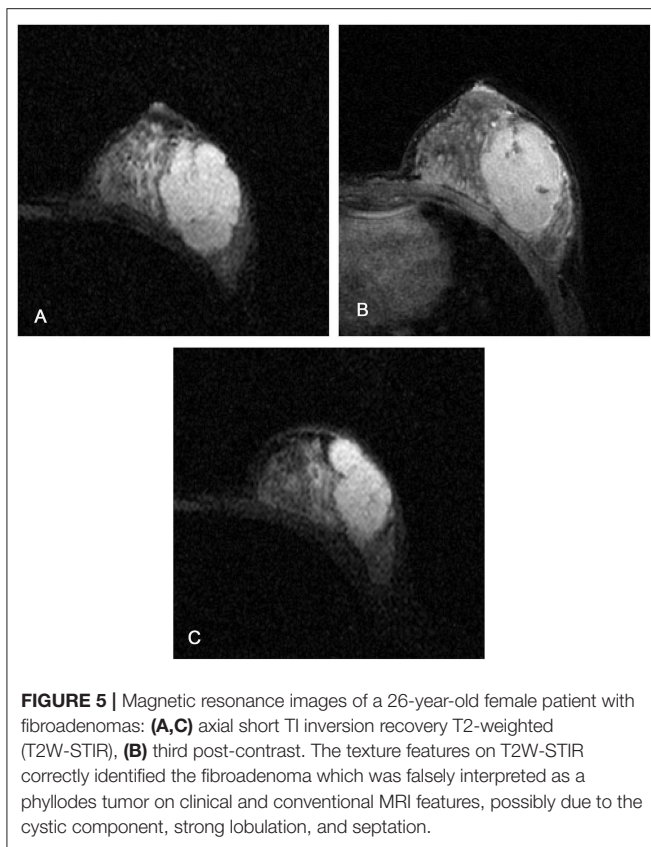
Magnetic resonance images of a 26-year-old female patient with fibroadenomas: (A,C) axial short T1 inversion recovery T2-weighted (T2W-STIR), (B) third post-contrast. The texture features on T2W-STIR correctly identified the fibroadenoma which was falsely interpreted as a phyllodes tumor on clinical and conventional MRI features, possibly due to the cystic component, strong lobulation, and septation.
